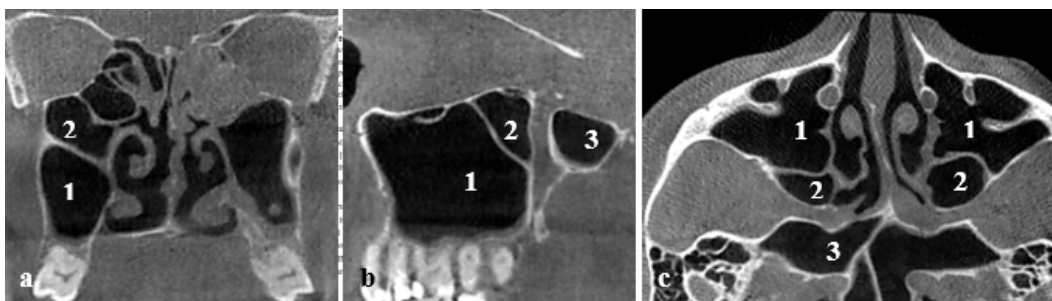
CBCT, coronal (a), sagittal (b) and axial (c) scans demonstrating ethmomaxillary sinus: 1 – maxillary sinus; 2 – ethmomaxillary sinus; 3 – sphenoid sinus
